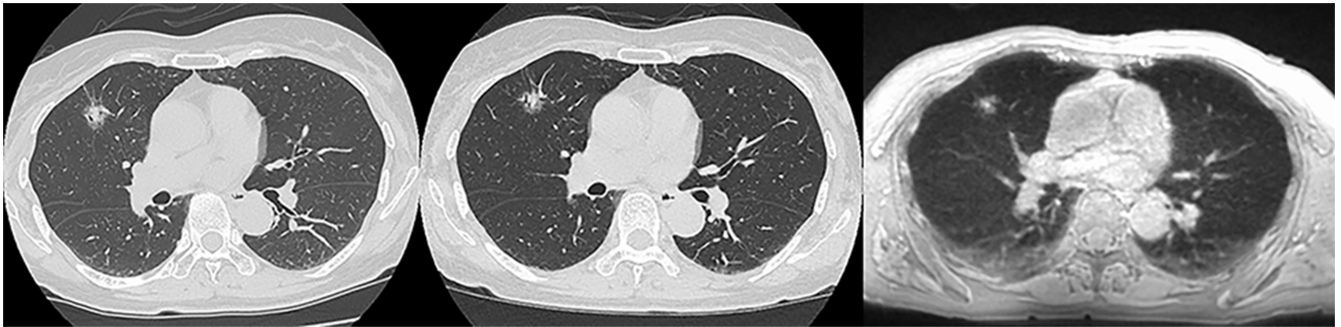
60-year-old male with part-solid nodule with 15-mm-long axis diameter and diagnosed as invasive adenocarcinoma (From left to right: standard-dose CT, low-dose CT, and pulmonary MR imaging with UTE). Standard- and low-dose CTs and pulmonary MR imaging with UTE clearly show a part-solid nodule with a 15-mm-long axis diameter in the right upper lobe. (Reproduced, with permission, from reference No. 45) UTE, ultra-short TE.
